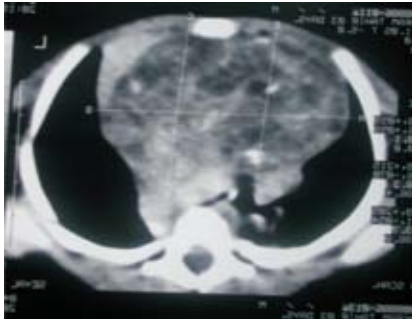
CT further elucidates the anterior mediastinal lesion obscuring the cardio shadow and producing cardio pulmonary functional compromise.
